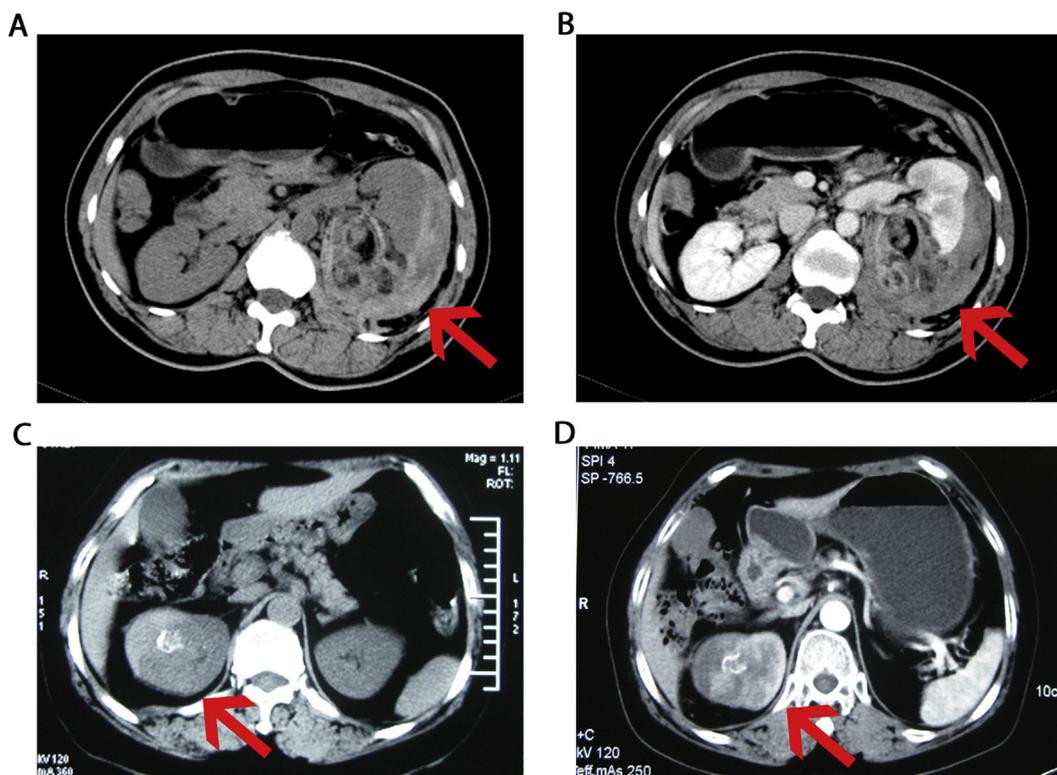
CT image of a solid neoplasm. A. plain CT image of angioleiomyolipoma (AML), B. enhanced CT image of AML, C. plain CT image of renal cell carcinoma (RCC), and D. enhanced CT image of RCC.
